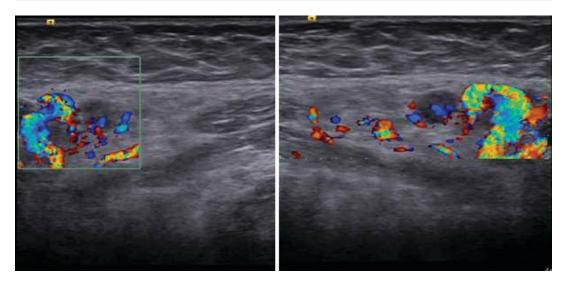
SCC. Color Doppler reveals peripheral vascularity of the lymph node which can be a precursor for metastasis
